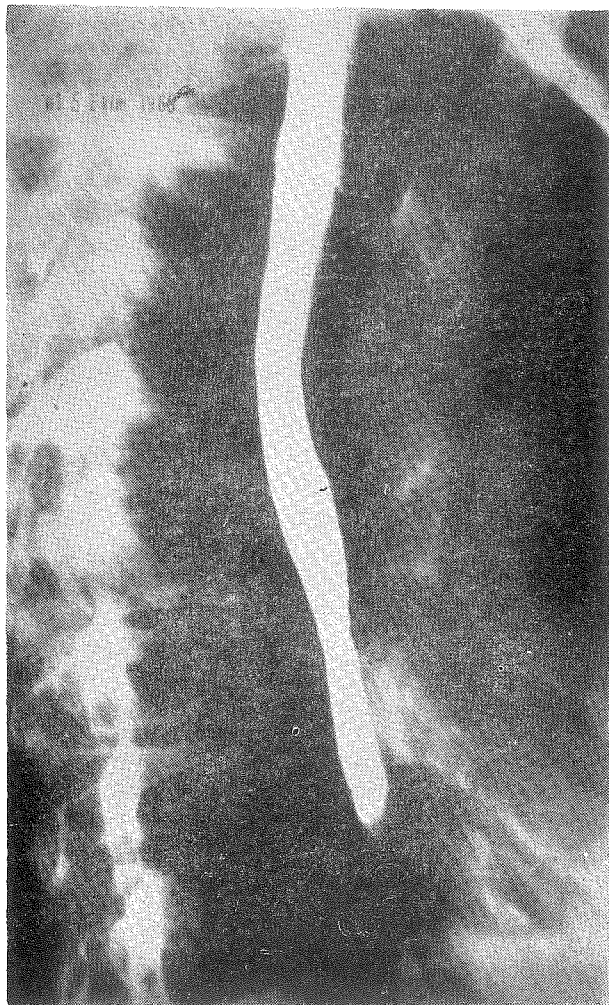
X-ray of the esophagus after dilatation.
